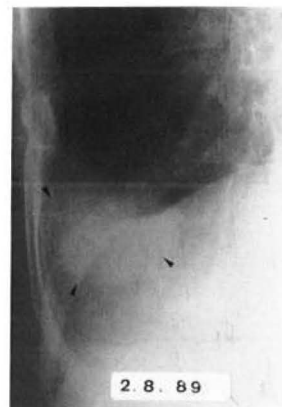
a: Chest X-ray taken in 1989; b: oblique view (1989).
